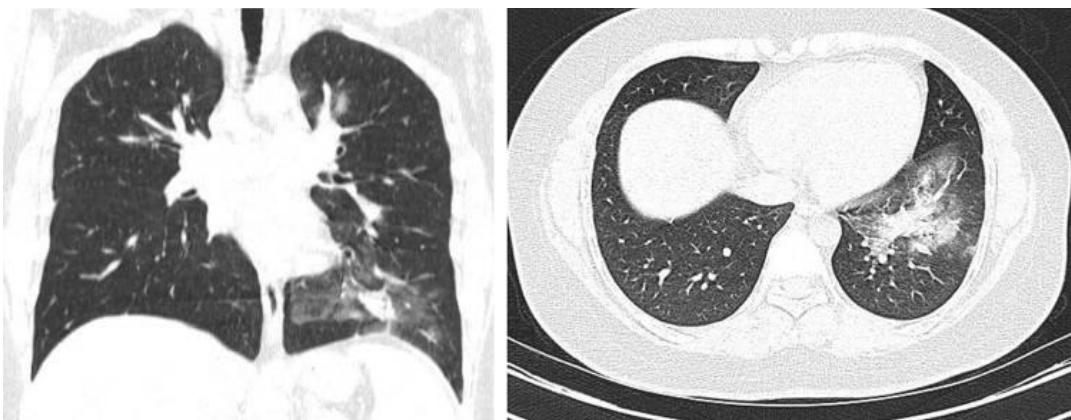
Coronal and axial without contrast-enhanced computed tomography (CT) image showing a coronavirus disease (COVID-19) infection
